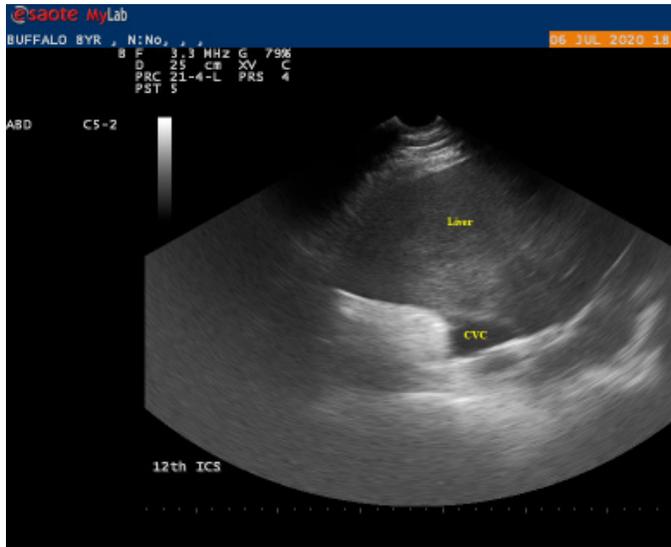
Sonogram of liver at dorsal portion of 12th ICS showing caudal vena cava (CVC) as a triangular anechogenic structure in transverse view.
